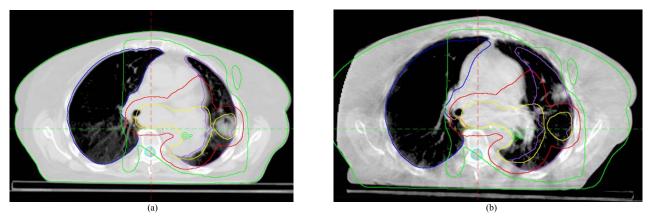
Inter-Fraction Tumour Migration Detected using On Board (kV) Cone Beam CT Imaging. a) Cone beam CT on first fraction of radiotherapy for non-small cell lung carcinoma demonstrating satisfactory coverage of target. b) A further cone beam CT at fraction 6 now clearly demonstrates that the primary tumour has now migrated out of the PTV.
